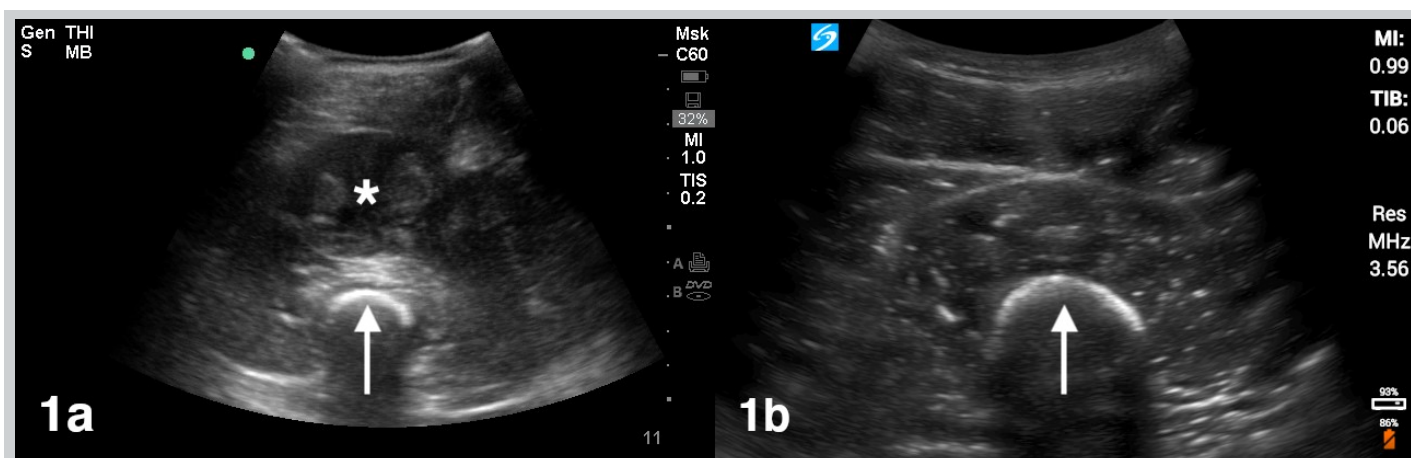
a) Ultrasound image of a large hematoma (asterisk) in the anterior thigh, appearing as a well circumscribed collection of mixed echogenicity. The femur (arrow) is the hyperechoic structure with posterior shadowing. b) Ultrasound image of a normal anterior thigh demonstrating normal sonographic muscle architecture with the femur (arrow) in the far field.
